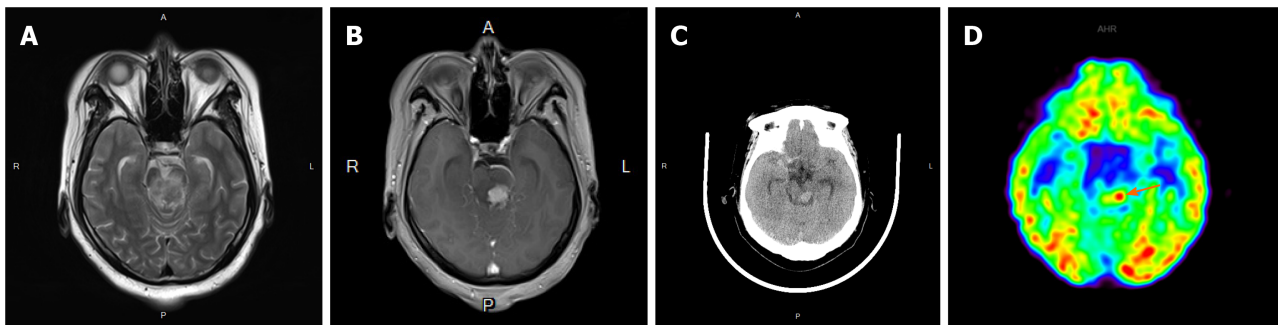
Imaging before treatment. A: Axial T2-weighted image shows heterogeneous intensity in the midbrain, and the midbrain aqueduct was compressed; B: Contrast-enhanced magnetic resonance imaging showing a significantly enhanced 1.9 cm × 1.8 cm-sized mass in the left midbrain; C: The lesion had high density on computed tomography; D: Fluorodeoxyglucose positron emission tomography showing that the lesion had increased glucose uptake (arrow). The maximum standardized uptake volume was 7.48.
